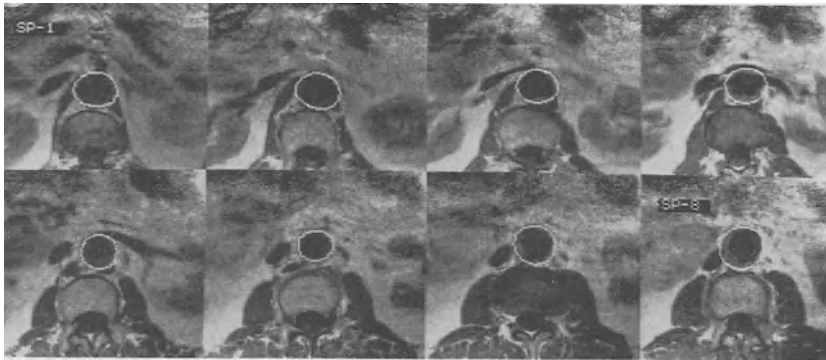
Resulting boundaries (white curves) of the outer wall of the aorta for the first eight successive sections of the diseased aorta in vivo data set which are superimposed on the  $T_1$  weighted MR images.
